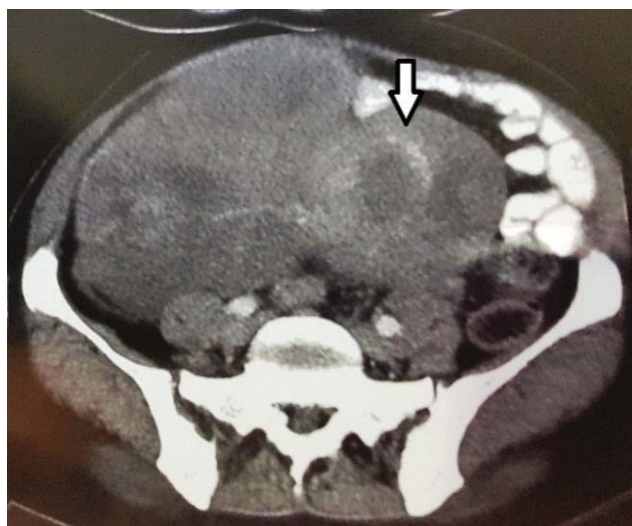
Abdominal Computed Tomography scan with contrast. The arrow shows the uterine mass.
